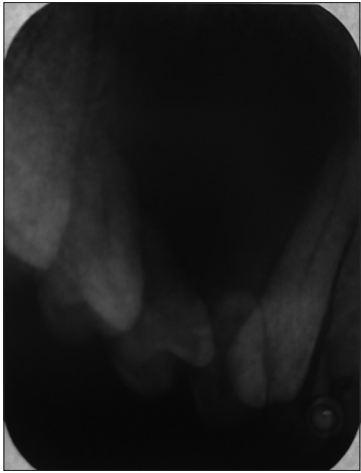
Intra Oral Periapical Radiograph it shows radiolucency in apical region of left deciduous maxillary lateral incisor
